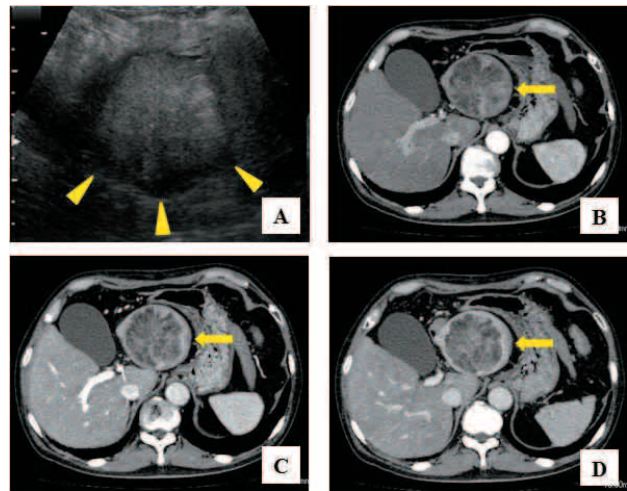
Ultrasonography showed the round high echoic tumor with the peripheral low echoic area in the left lobe of the liver (A, arrowheads). Dynamic contrast-enhanced computed tomography (CT) in the arterial phase demonstrated irregular enhancement in the tumor (B, arrow). The portal and venous phases also showed the irregular internal enhancement without wash-out (C, D, arrow).
